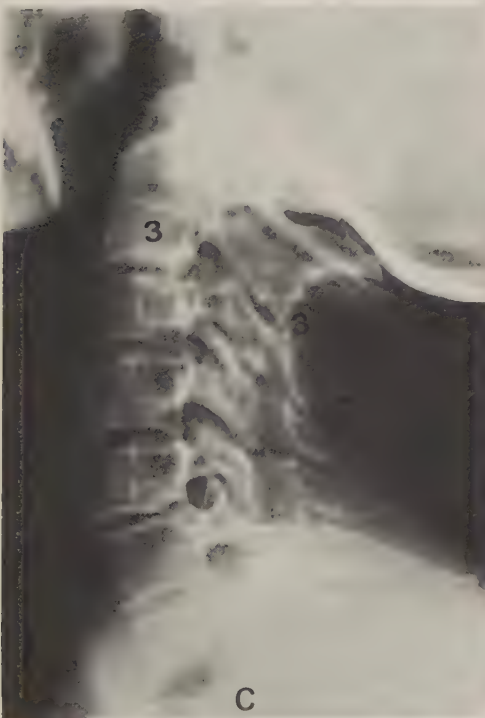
(Opposite side) CASE 1. a) Cervical lateral radiograph from 1971 with no arthritic changes of the subaxial region. Sagittal spinal diameter was 20 mm at the C3 - C4 level. b) Lateral radiograph from 1974 with small subaxial dislocations at C3 - C4 and C4 - C5 levels. c) Lateral cervical radiograph from 1978 with a deterioration of the dislocation at the C3 - C4 level, as well as of other arthritic changes. d) Lateral tomogram of the cervical spine in 1981 showing the remnants of the body of the C3 vertebra situated in front and slightly caudad to the C4 body. The spinous process belonging to C3 is situated dorsally to the C4 body and above the corresponding process of C4. Sagittal spinal diameter is diminished to 10 mm. There are also severe changes at the C6 - C7 level.
